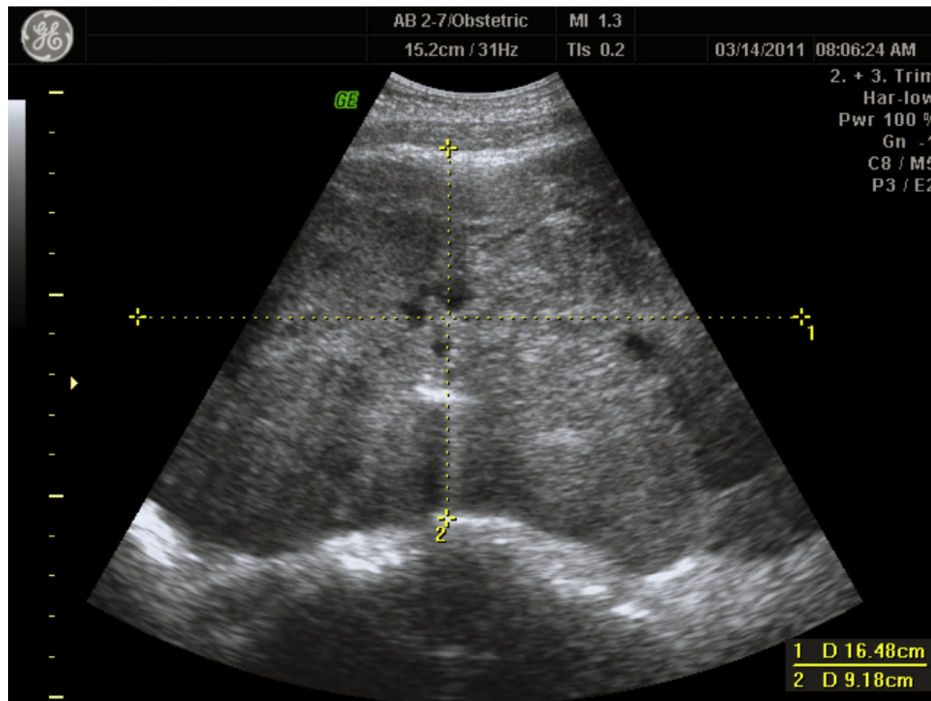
Ultrasonography shows a huge, solid, heterogeneous tumor in the pelvic cavity.
